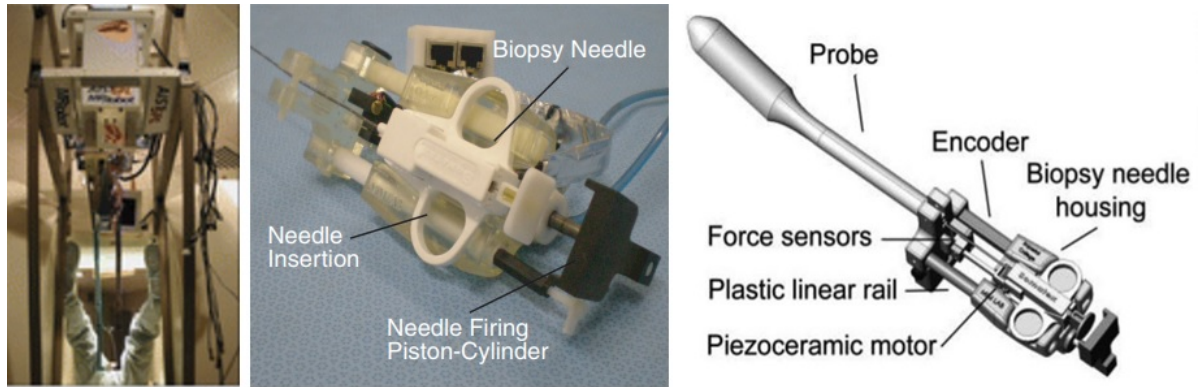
Piezoelectrically actuated robots in literature. Left) a robot for prostate biopsy implemented in an open MRI scanner [47], Middle) A transrectal approach for prostate biopsy using piezoelectric actuation [27], Right) A render of biopsy unit for prostate biopsy using PiezoLEGS motors [49].
